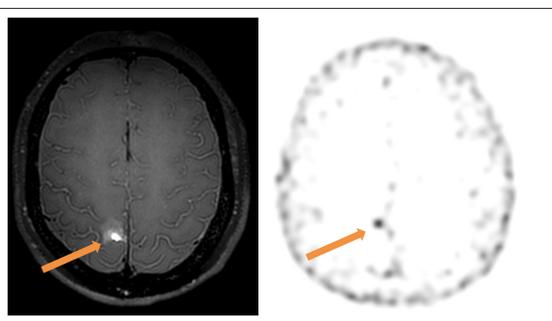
brain lesion of 8 mm after external beam radiation poses a differential diagnosis between radionecrosis and disease recurrence. The HER2-tracer shows accumulation in the lesion, and MRI after 3 months confirmed disease progression.
